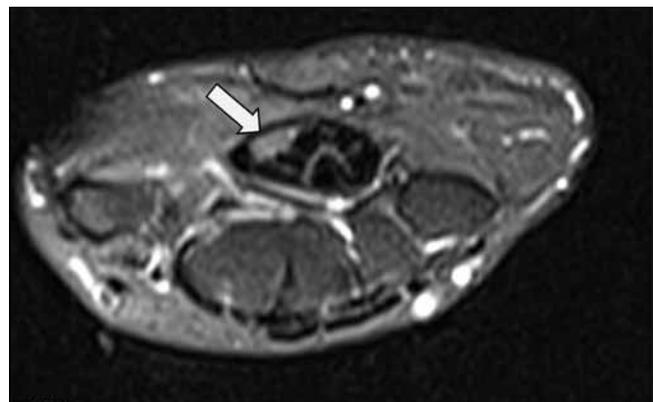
White arrow in T2-weighted MRI appearance of advanced-level CTS (white arrow: median nerve).
